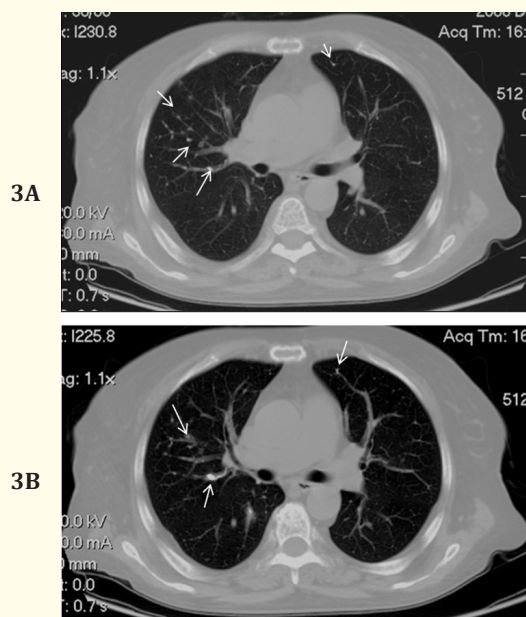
3B: Axial thorax CT shows multiple linear and nodular hiperdensities in bilateral lobar and segmental pulmonary artery branches(arrows).
